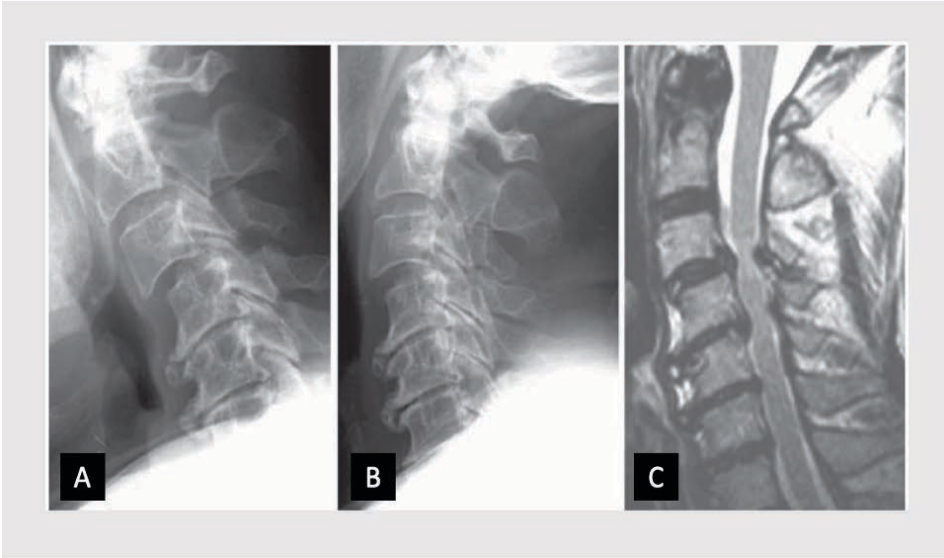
Spondylolisthesis: Anterolisthesis- Lateral radiographs of the cervical spine of a 68- year- old patient with the neck in flexion (A) and in neutral position (B). Sagittal T2-weighted magnetic resonance imaging (MRI) scan indicates anterolisthesis (C).¹⁸⁰
